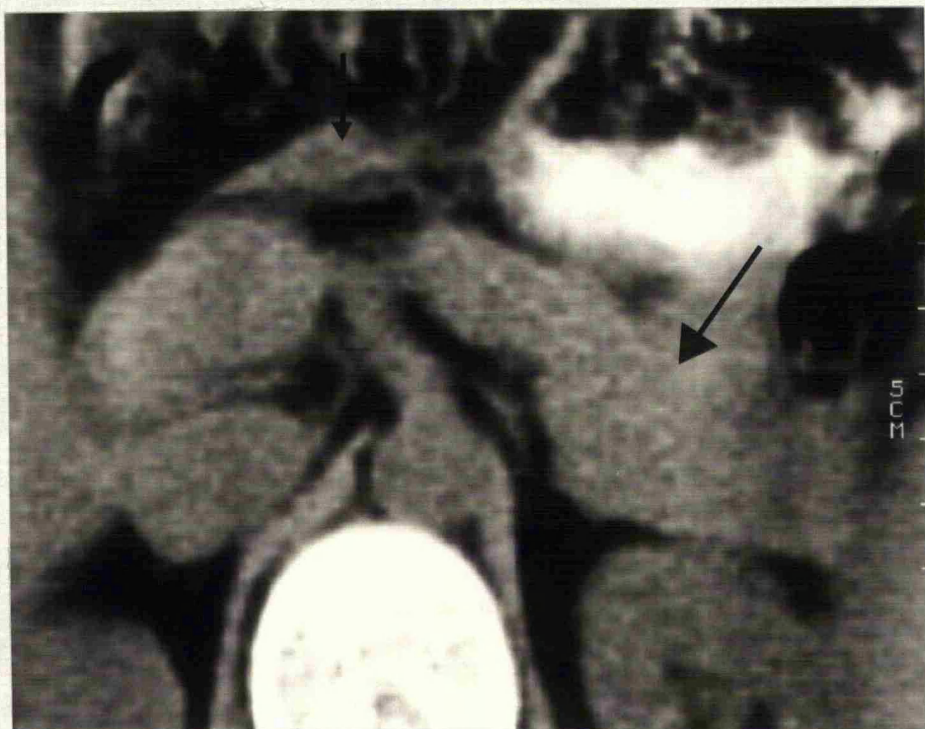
Conventional unenhanced CT (above) and perfusion (below) images from case 3. Large arrow: native pancreas; small arrow: transplant pancreas.
